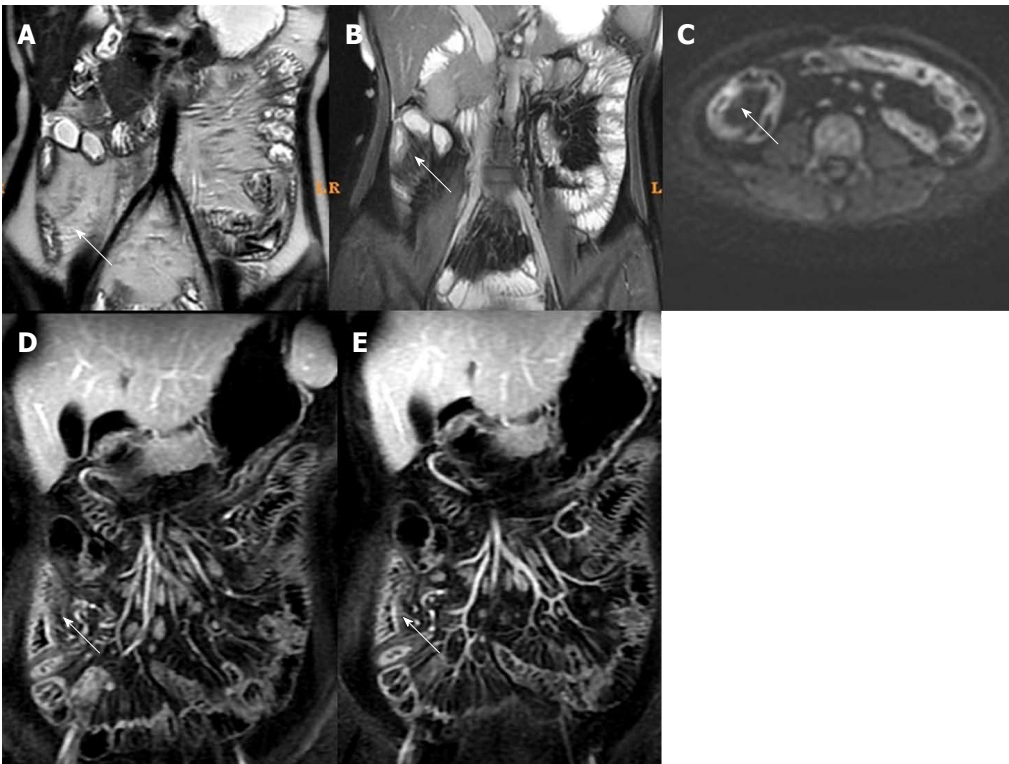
Magnetic resonance imaging of a typical case of active Crohn's disease before treatment. Male, 25 years of age, active Crohn's disease. A: Fast imaging employing steady-state acquisition showed intestinal wall thickening and submucosal edema in the ascending colon; B and C: T2WI showed intestinal wall thickening and submucosal edema in the ascending colon; D and E: Dynamic enhancement showed obvious enhancement; F: Diffusion weight imaging showed marked high intensity.
